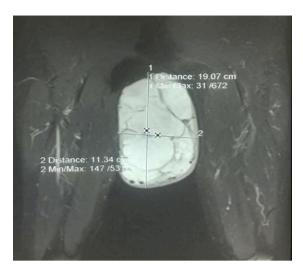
MRI coronal section in T1gado sequence.
